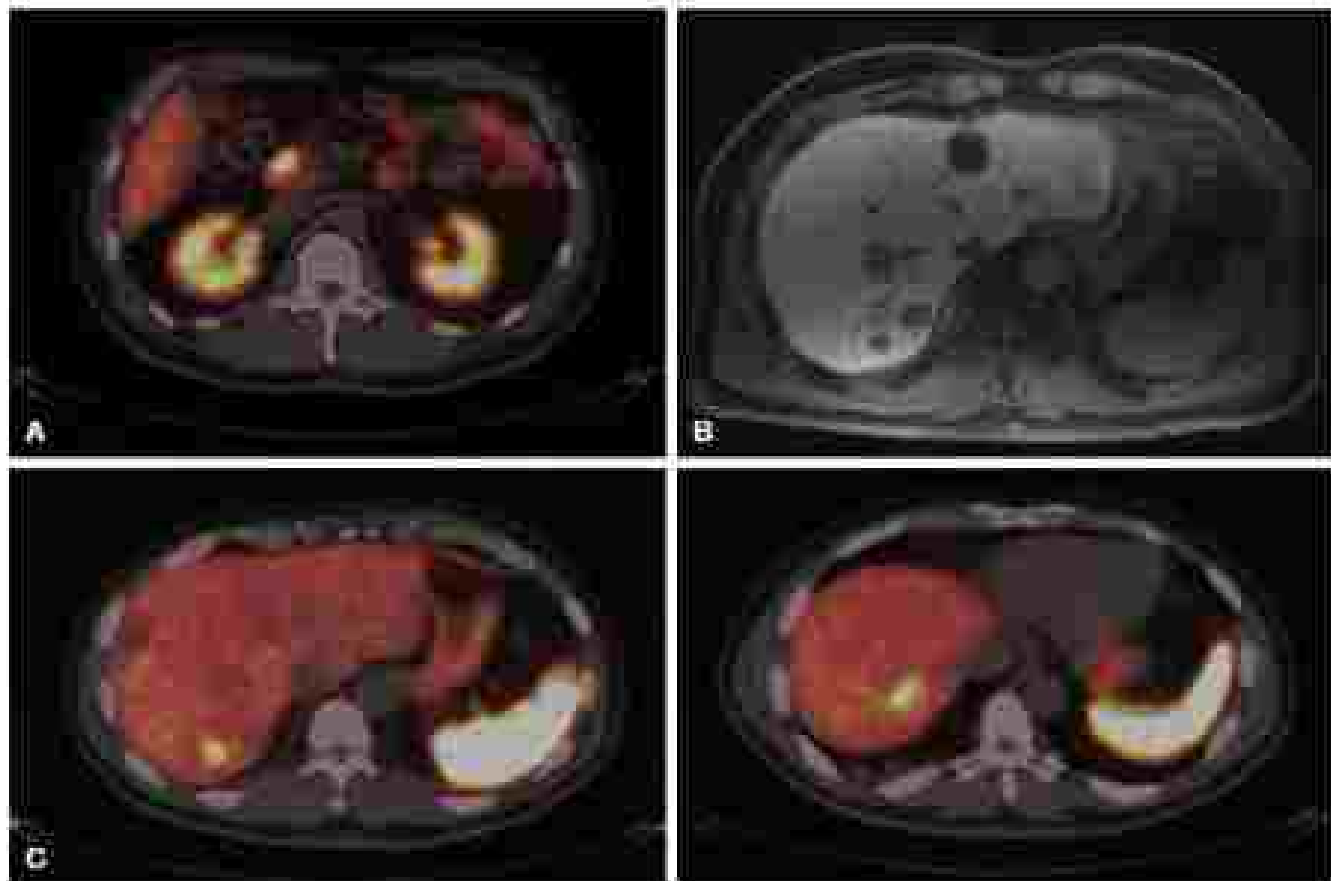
(A) DOTATOC positron emission tomography scan showing a primary 1-cm pancreatic neuroendocrine tumor in the head of the pancreas. (B) Low-resolution magnetic resonance imaging of the liver in the same patient suggesting multiple hyperintense liver metastases such that the patient was thought to be unresectable and he was given everolimus for 1 month without benefit. (C) The same DOTATOC scan at level as (A) showed only two liver metastases and both were located in the posterior sector of the right lobe. Because of the resectable pancreatic neuroendocrine cancer based on the DOTATOC scan, the patient underwent Whipple's procedure with right posterior resection and was disease free.
